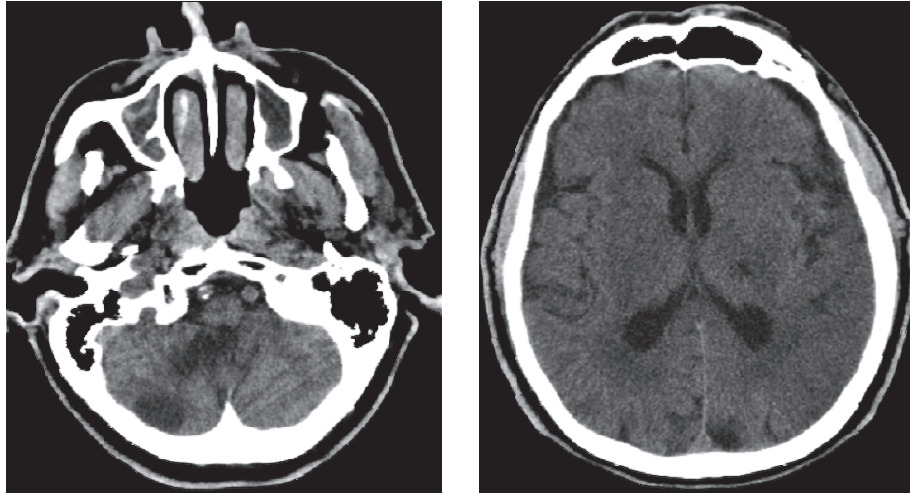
D.R., 65 years old, known with type 2 diabetes mellitus, arterial hypertension and hypercholesterolemia, admitted with left hemihypoesthesia. CT-scan shows mixed brain atrophy and right thalamic lacunae.
